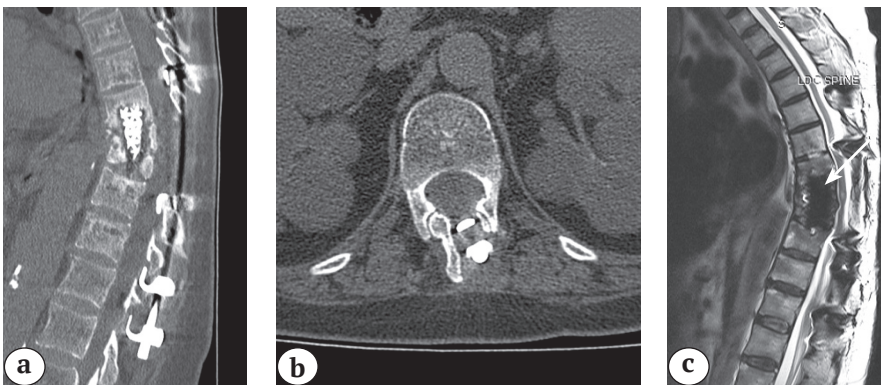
MSCT (a, b) and MRI (c) of the spine in 2 years and 9 months after the initial spine reconstruction and in 13 months after the posterior stabilization: resorption of the Th12 vertebra arch under the caudal support hook. Myelopathic lesion is indicated by an arrow
